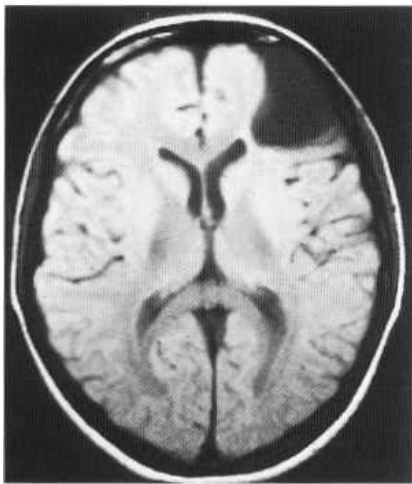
MRI study of left anterior temporal arachnoid cyst, proton density. (Courtesy of Dr Gordon Thomson and Bristol MRI Centre.)
